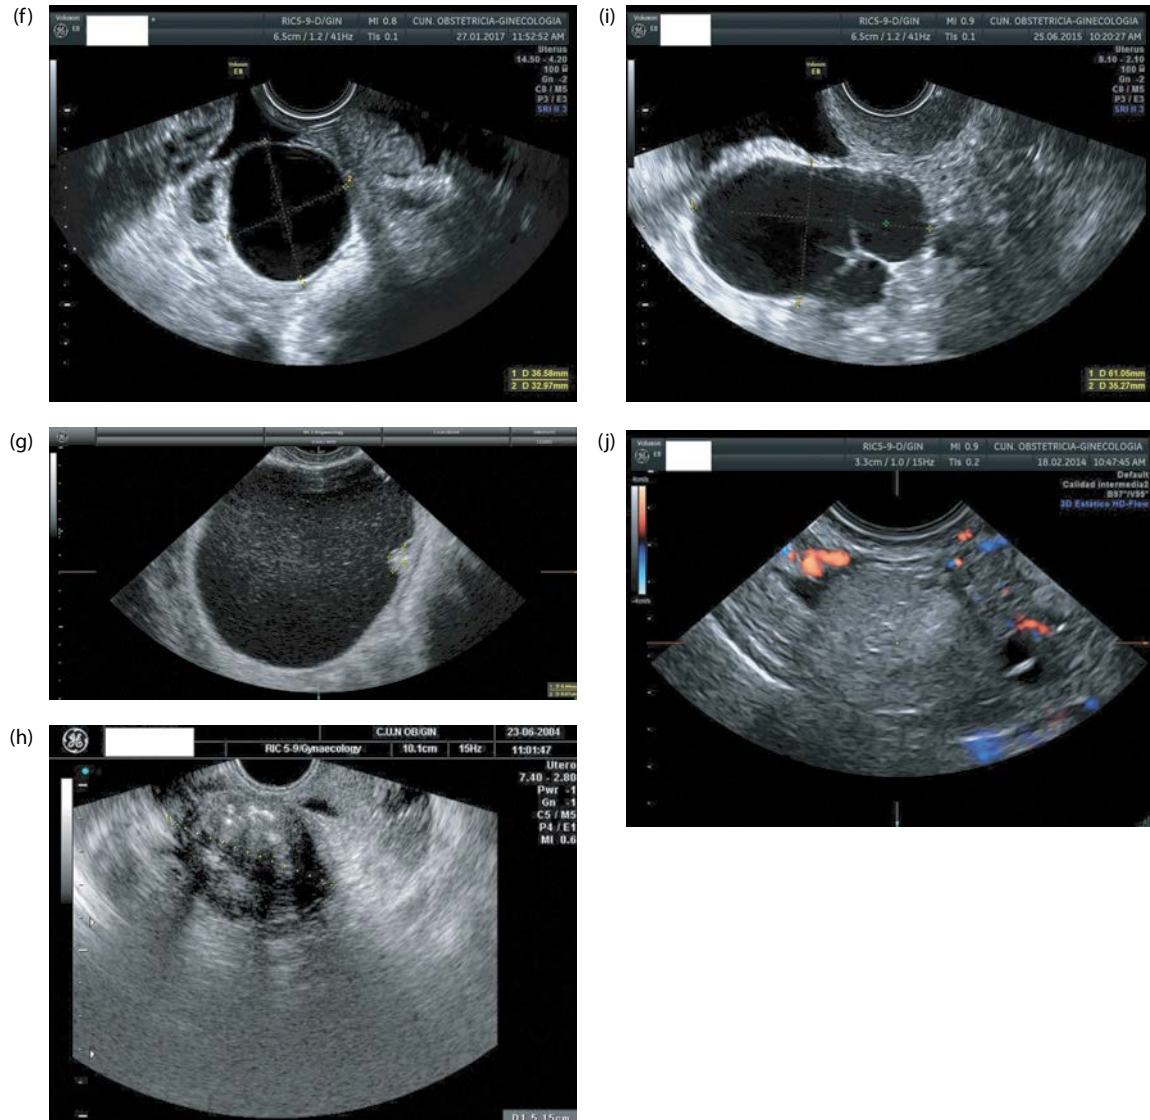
(Continued) Examples of ultrasound features of IOTA simple rules. (f) B1 (unilocular cyst); (g) B2 (presence of solid components less than 7 mm); (h) B3 (presence of acoustic shadowing); (i) B4 (smooth multilocular tumor <100 mm); (j) B5 (color score 1).
